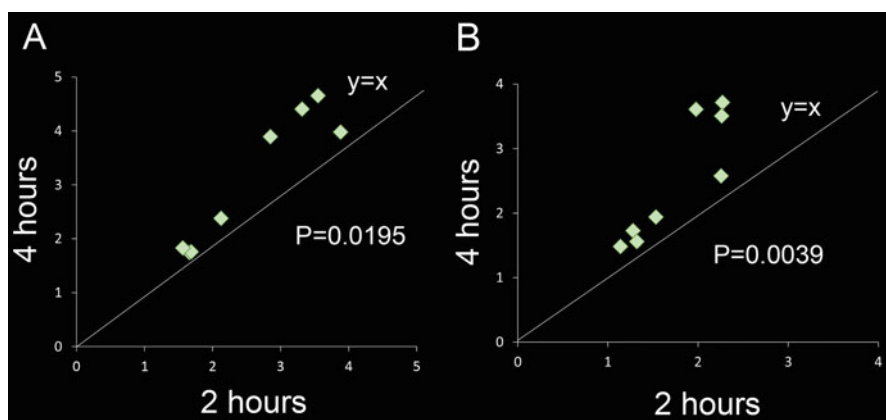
All glioblastoma cases showed increases in both the (a) SUV_{max} and (b) tumor-to-normal ratio from 2 h to 4 h
